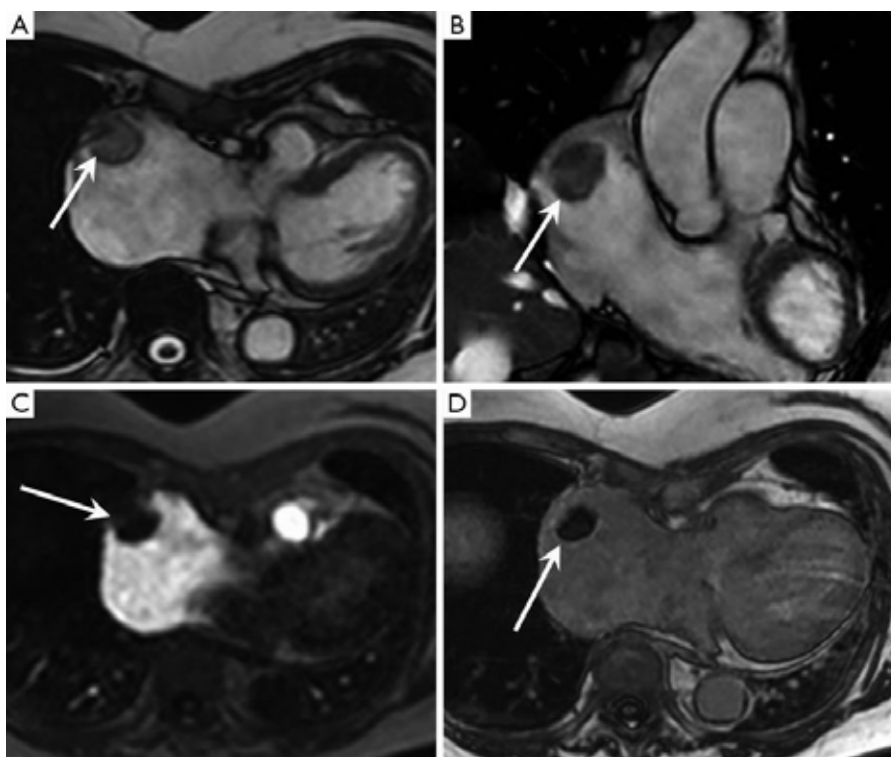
Right atrial thrombus on MRI. (A) Axial SSFP image showing a 3 cm well circumscribed mass within the right atrium (arrow); (B) coronal SSFP image again showing the right atrial mass with no sign of invasion into the atrial wall (arrow); (C) axial image from a resting perfusion study showing an absence of first pass contrast enhancement (arrow); (D) axial late phase inversion recovery image with an inversion time of 600 ms post gadolinium showing the mass of uniformly low signal which is a characteristic feature of thrombus (arrow)
